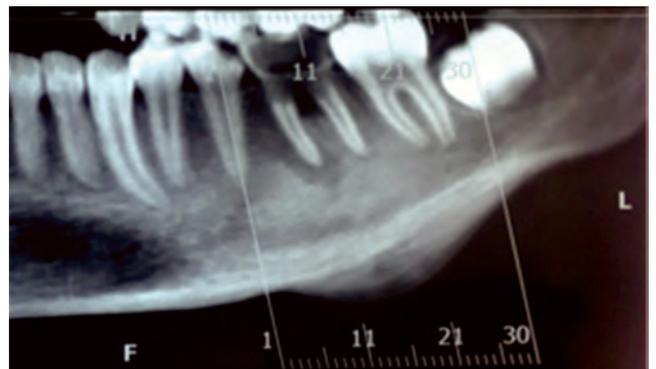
Panoramic reconstruction of cone beam CT showing an extensive radiolucent image associated with the first mandibular molar, with bone rarefaction and radiopaque bone laminations on the cortical surface resembling "onion peels."
